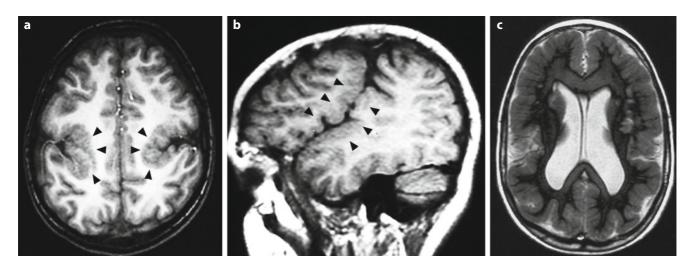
Brain MRI scan in two patients with PMG (a and b belong to the same patient). a Axial section, BPP. The sylvian fissures are open and the perisylvian cortex is thickened and irregular (*arrowheads*). b Sagittal section. Note the abnormal vertical orientation of the sylvian fissure, which appears to be fused with the rolandic fissure. c Axial section. BFPP in a girl with a *GPR56* mutation and Lennox-Gastaut syndrome
